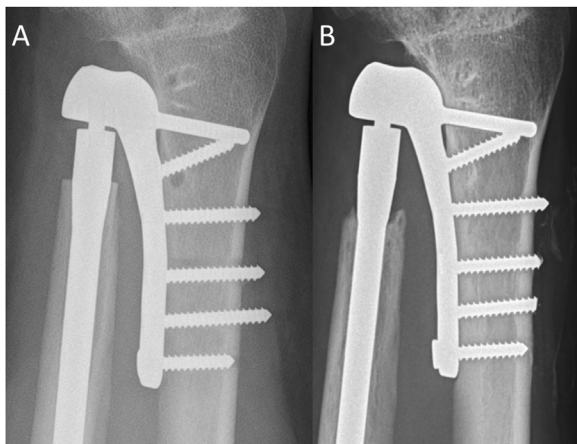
Postoperative X-ray in patient 3 shows protruding screws of the radial component (A). The protruding screws were cut using a cebotome (B).
